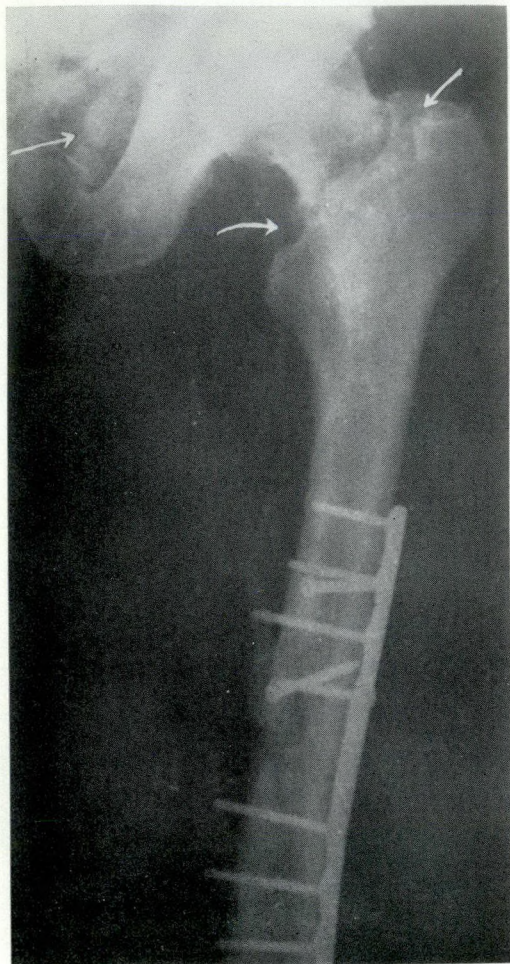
Case 1. Check radiograph two months after injury. Note the fracture of the femoral neck.
